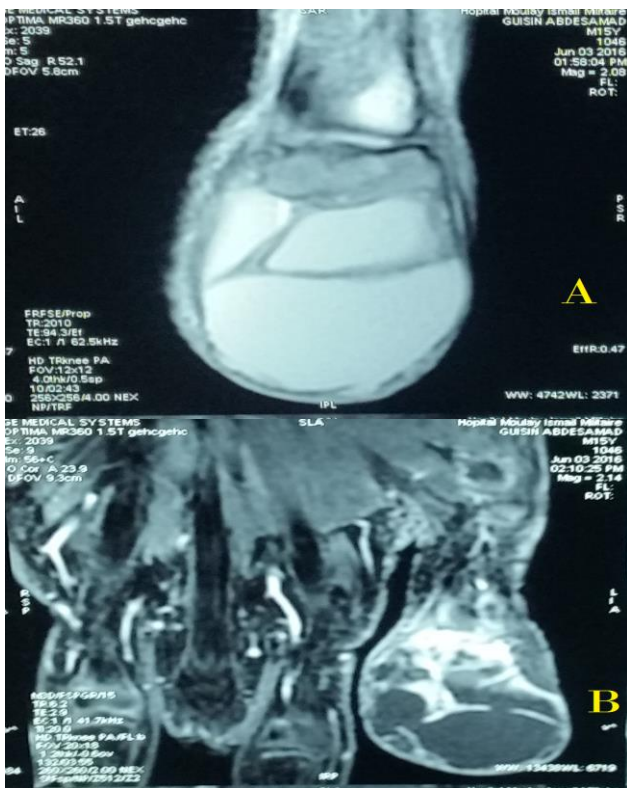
(A and B): MRI appearance of the P2 mass of the left thumb of hypo T1 hyper T2 heterogeneous fluid signal vascular septum at the periphery after gadolinium injection measuring 37x35 mm, single blowing the bone cortical and thinned the soft parts.
